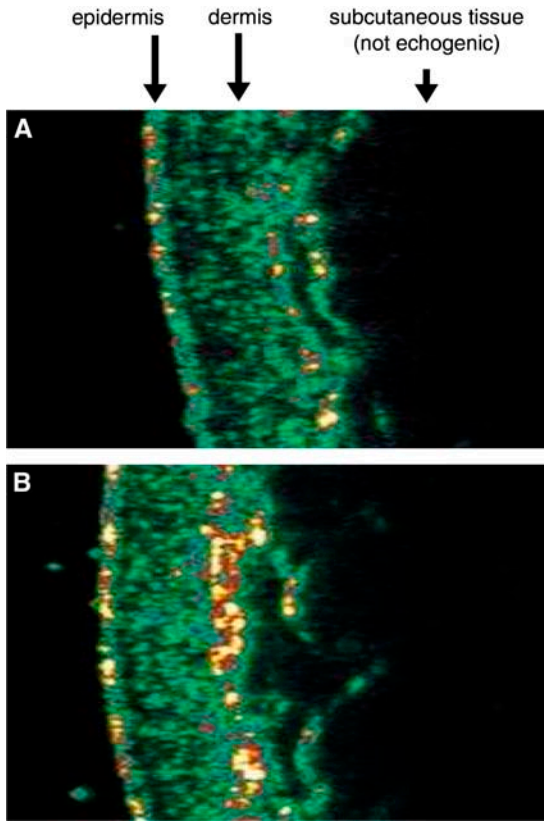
Examples of high-frequency ultrasound B-scans showing skin density of women at wk 0 (A) and after 12 wk of consuming high flavanol cocoa beverages (B) (see Table 4).
